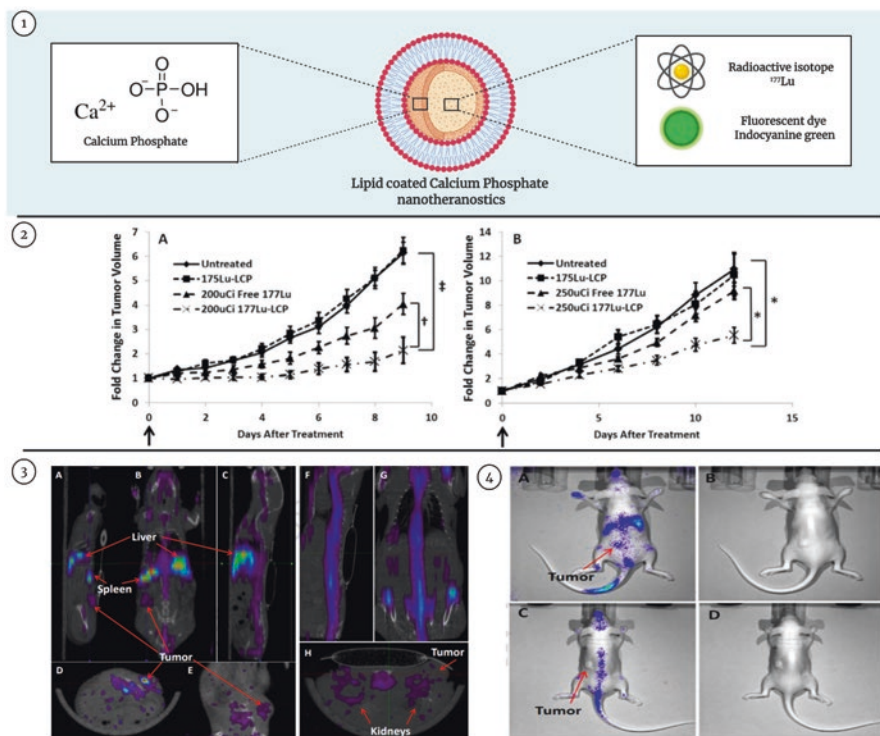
(1) General structure of Lipid protected calcium phosphate nanotheranostic. (2) Increase in tumor volume followed by treatment with placebo (untreated), ¹⁷⁵Lu-L-CaP, 200nCi free ¹⁷⁷Lu and 200nCi ¹⁷⁷Lu-L-CaP (Satterlee et al., 2015). (3) SPECT imaging obtain 24 hours post injection of ¹⁷⁷Lu-L-CaP showing the improved accumulation of nanosystem (A–E) in tumor, liver, and spleen, whereas plain ¹⁷⁷Lu (F–H) was concentrated in bone and kidneys. (Reprinted with Permission from Satterlee et al., 2015). (4) Cerenkov luminescence imaging post treatment showing liver, spleen, and tumor accumulation of ¹⁷⁷Lu-L-CaP (A). Whereas free ¹⁷⁷Lu (C) accumulates in bone and particularly spine. (Reprinted with Permission from Satterlee et al., 2015)
